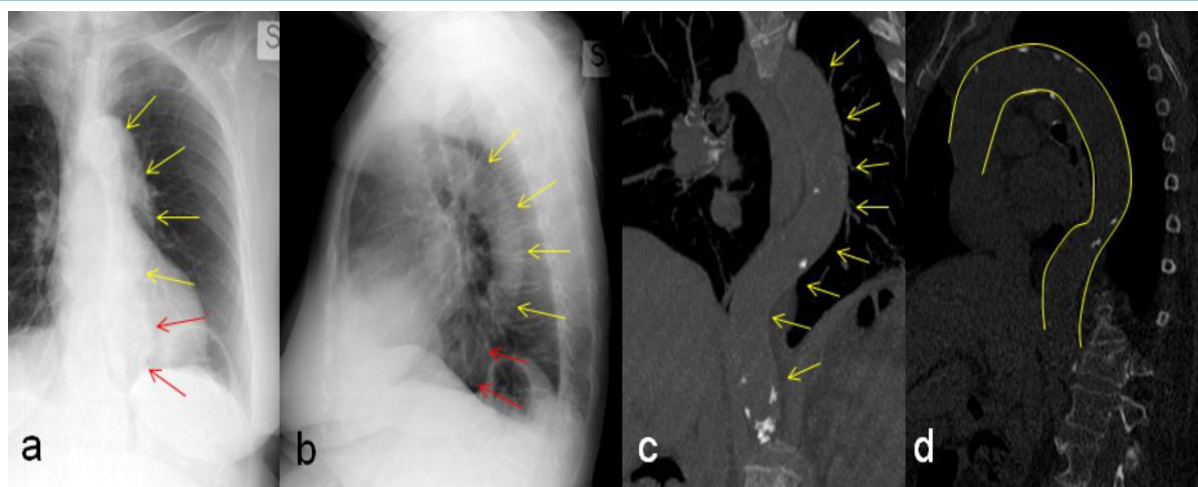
Chest X-ray (a,b) in a 70-year-old-man showing enlargement, elongation and tortuosity of the thoracic aorta (yellow arrows). Coronal (c) and sagittal MPR reconstructions (d) confirm the same findings. In this patient also coexist a hiatal hernia (red arrows in a and b).
